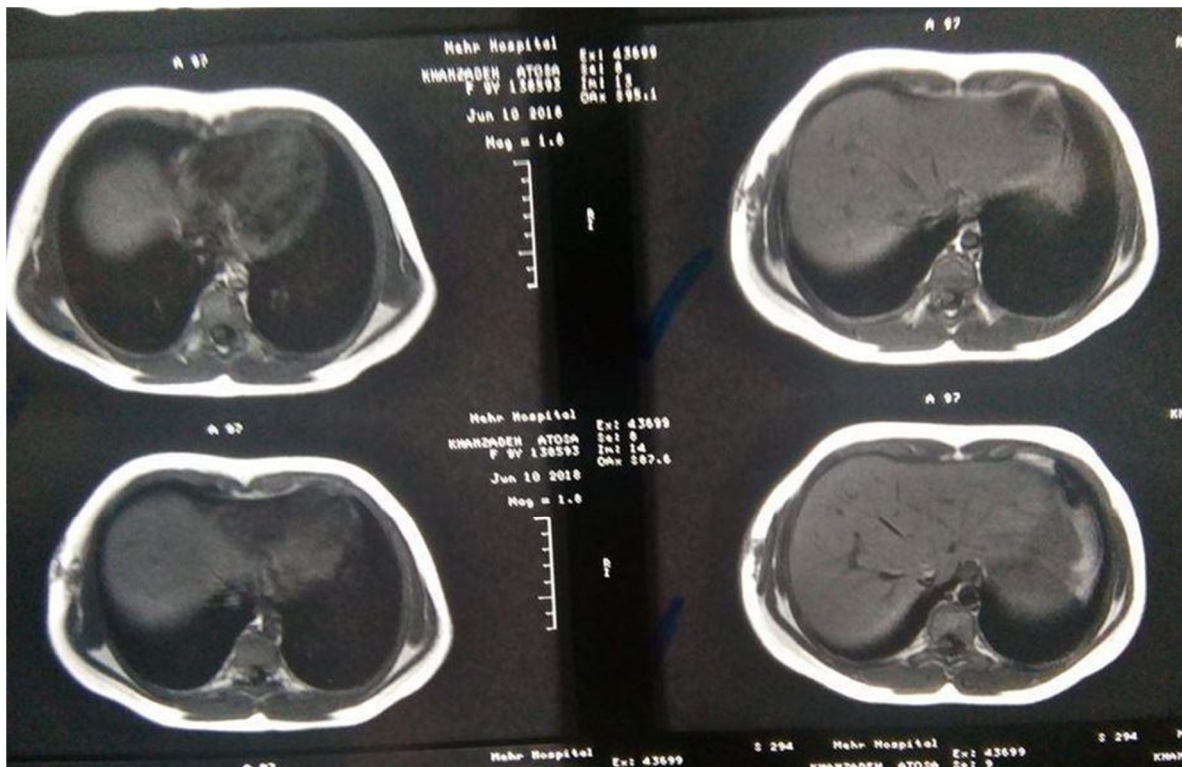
MRI of the chest. T1- weighted, without contrast and without fat suppression.
